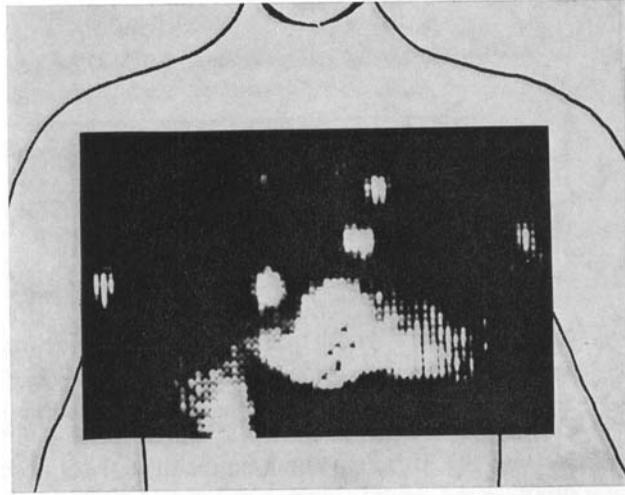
Static image 4 hours after the injection of $^{99}\text{Tc}^m$ -sulphur colloid in a patient. Uptake into 3 parasternal nodes to the left of the sternum and into 2 nodes to the right. Accumulation into each axilla from the site of subcutaneous injection 1 cm from the xiphoid process.
